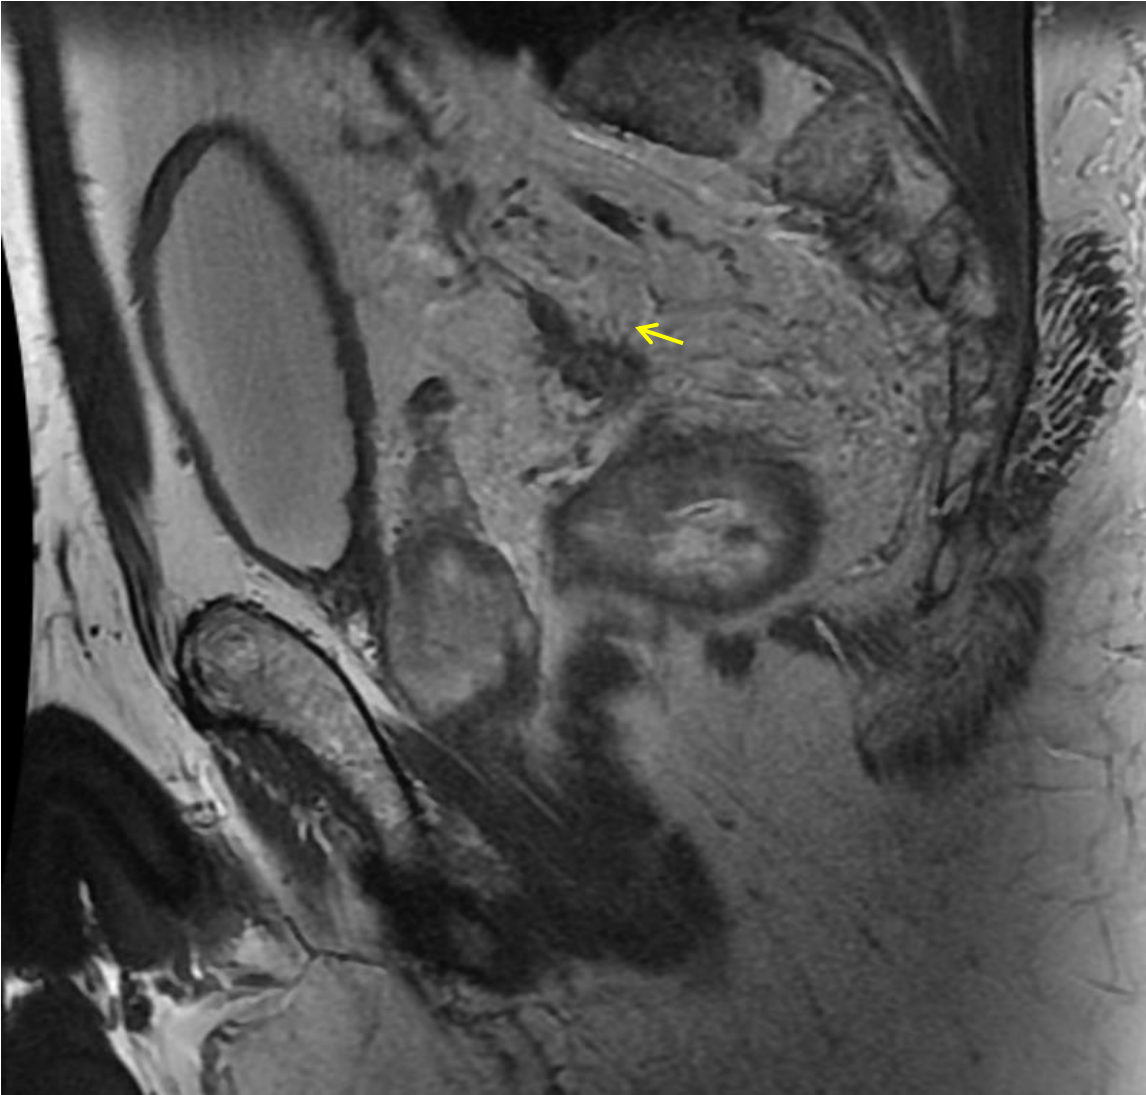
(Case 201) Coronal and sagittal MRI images of a 56-year old male patient with a locally advanced mid- to upper rectal cancer staged cT4aN1b, with extramural venous invasion (yellow arrow)
